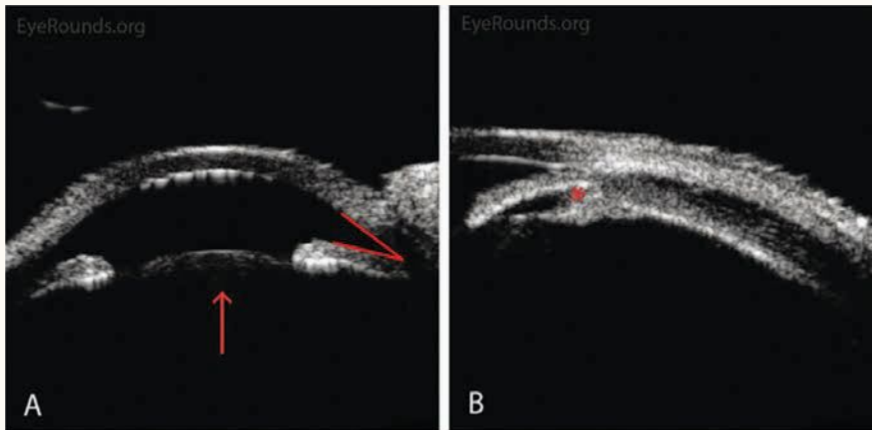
Anterior segment ultrasound shows a shallow anterior chamber, narrow angle, forward-displaced lens and anteriorly rotated ciliary body.
